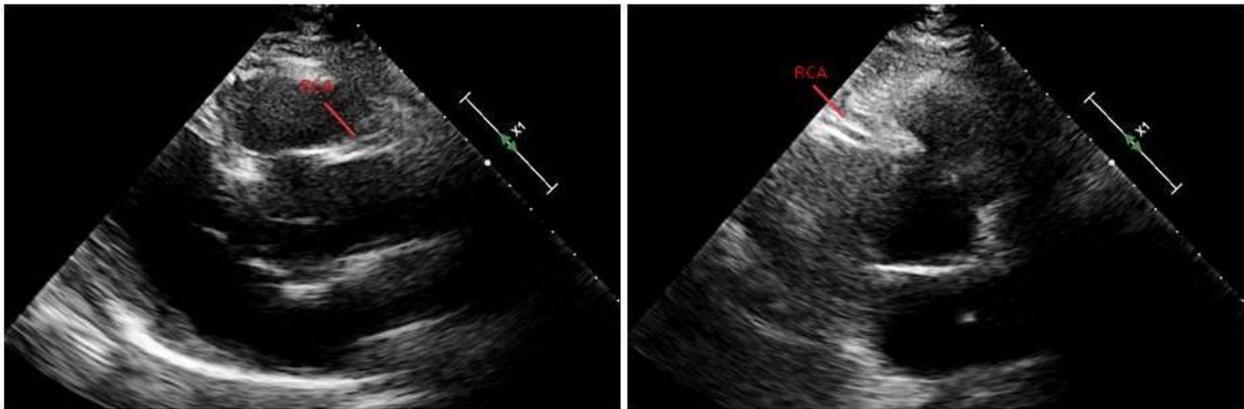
Ultrasound (US) evaluation of the right coronary artery (RCA) in the patient. The RCA, followed for proximally 4 cm appears to be of a normal caliber and with normal wall thickness.
